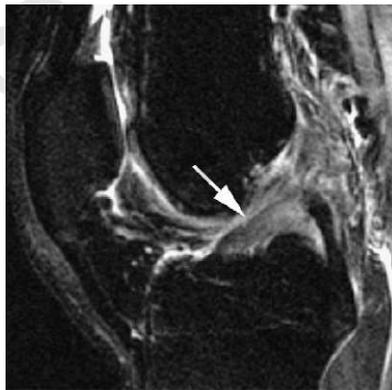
Partial-thickness tear of the ACL on sagittal fat-suppressed proton density MR imaging. The ACL (arrow) has diffusely increased signal. The normal parallel course of the fibers is disrupted. The ACL also has an abnormally horizontal orientation.⁽¹²⁾
